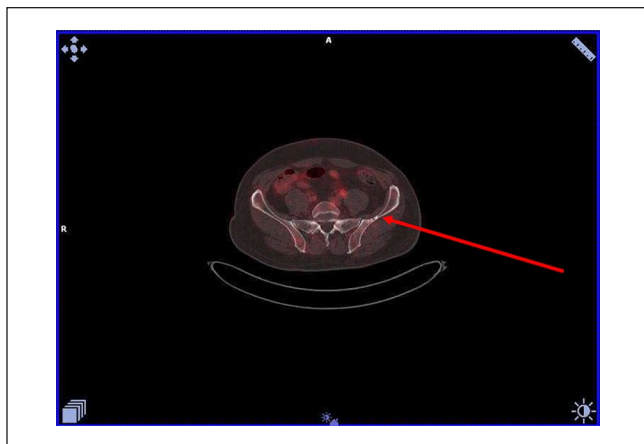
PSMA-PET showing a lesion in the iliac crest (red arrow), but without uptake (yellow).
